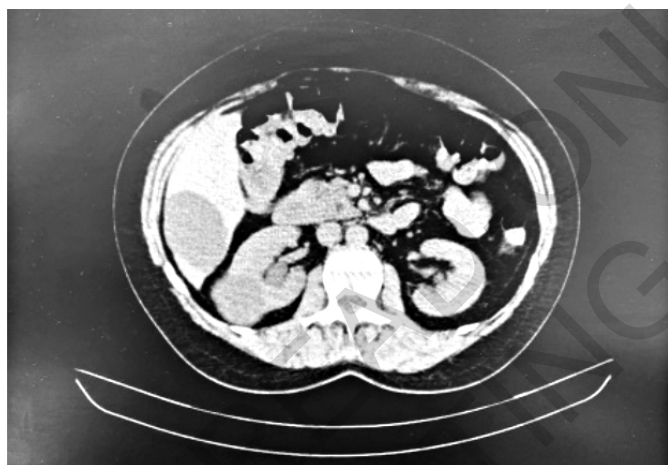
Abdomen CT scan case 2.
